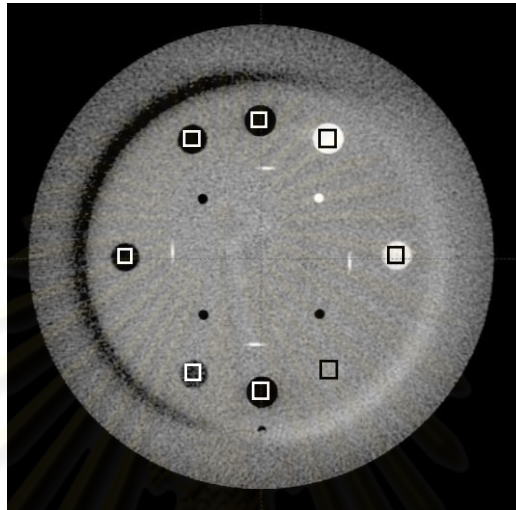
Measurement of CT number on CBCT image dataset.
